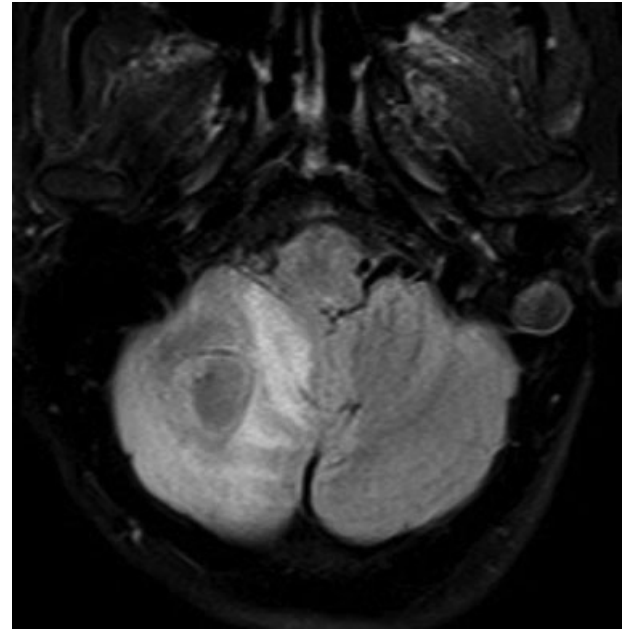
FLAIR sequence shows perilesional edema.
